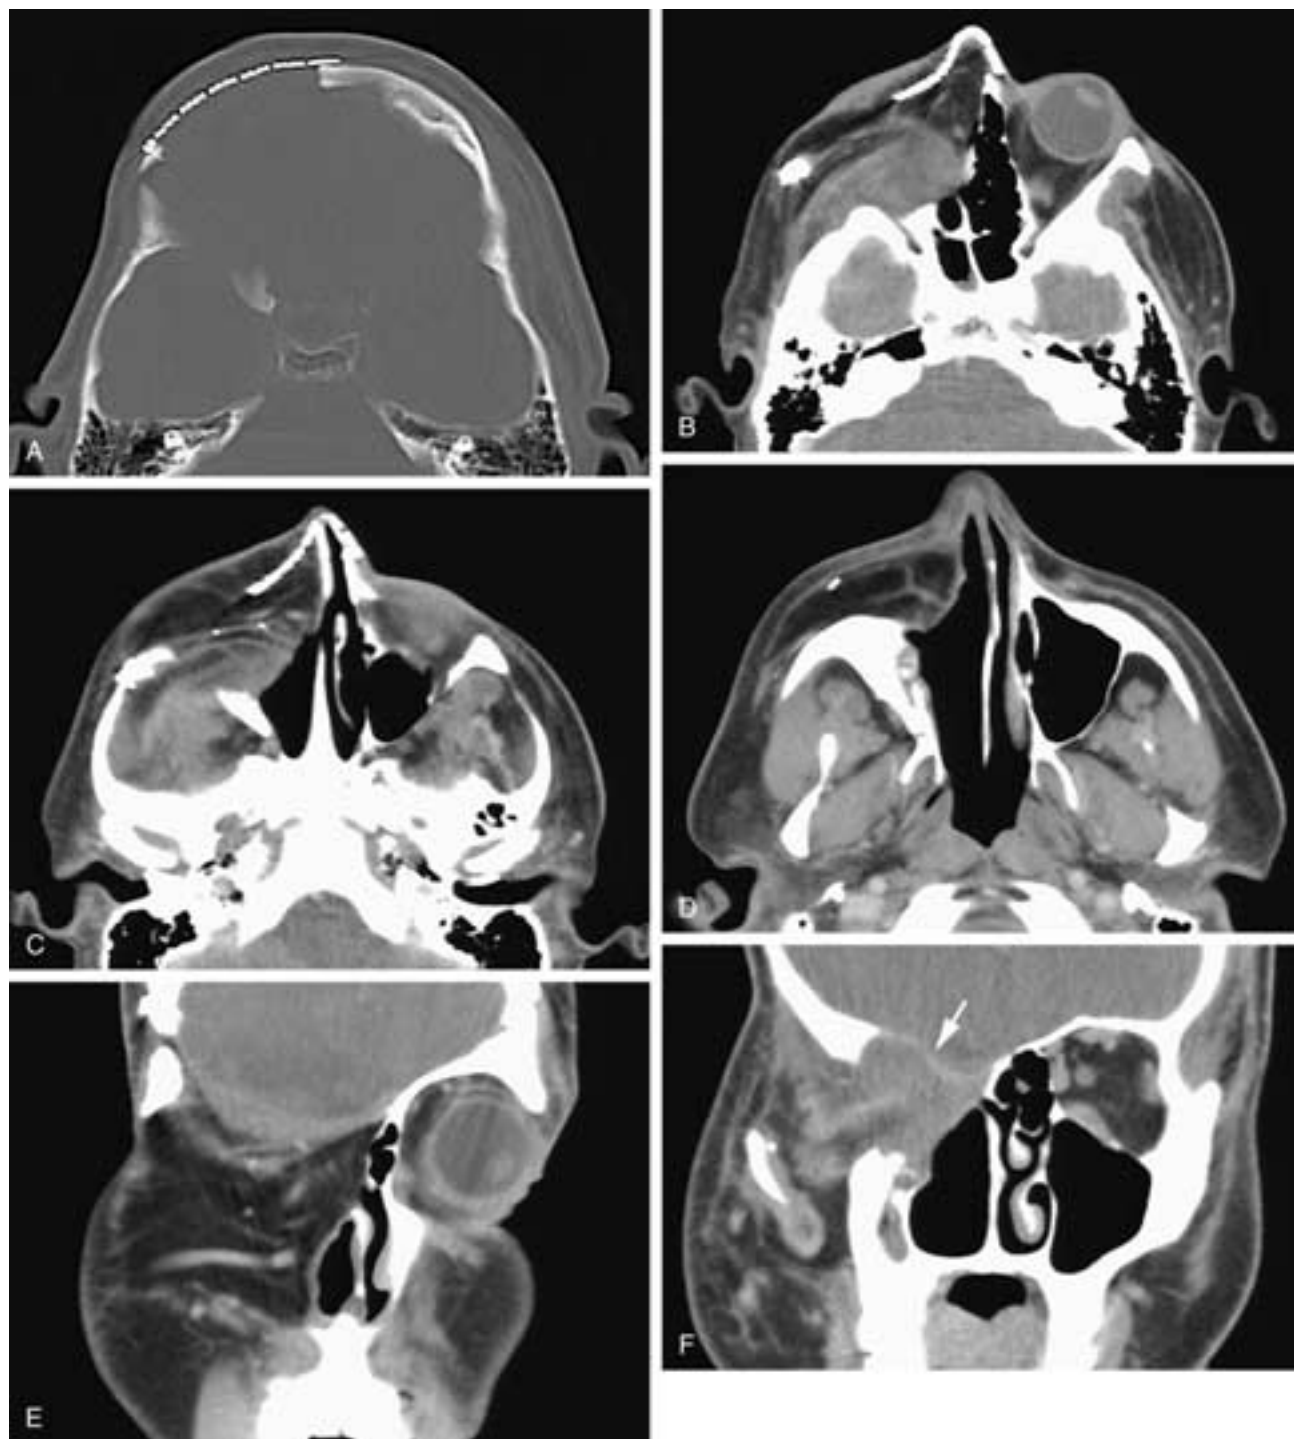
Serial axial CT scans from cranial (A) to caudal (D) and coronal CT scans from anterior (E) to posterior (F) on a patient who has had a craniofacial procedure, with a myocutaneous graft replacing the right orbit and face. Metal plates have been used to form a nasal contour. Although soft-tissue attenuation is seen near the cranial margin of the craniofacial graft, the intracranial margin (*arrow*) is smooth, as is the sinonasal margin. No recurrence is present.
